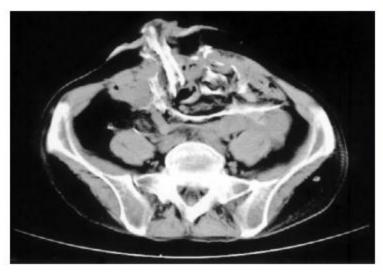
Noncontrast computed tomography demonstrates extensive heterotopic ossification in the abdominal midline incision, mesentery of small intestine, and perileostomy tissue.
